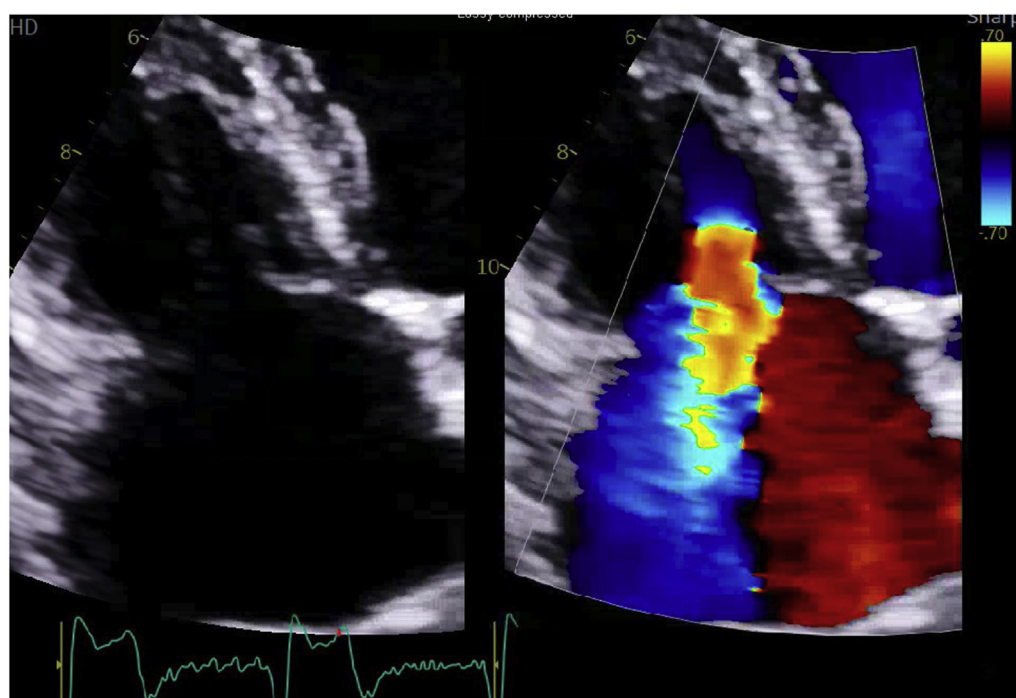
Transthoracic echocardiogram after LP insertion showing severe TR on a focused RV apical view.
